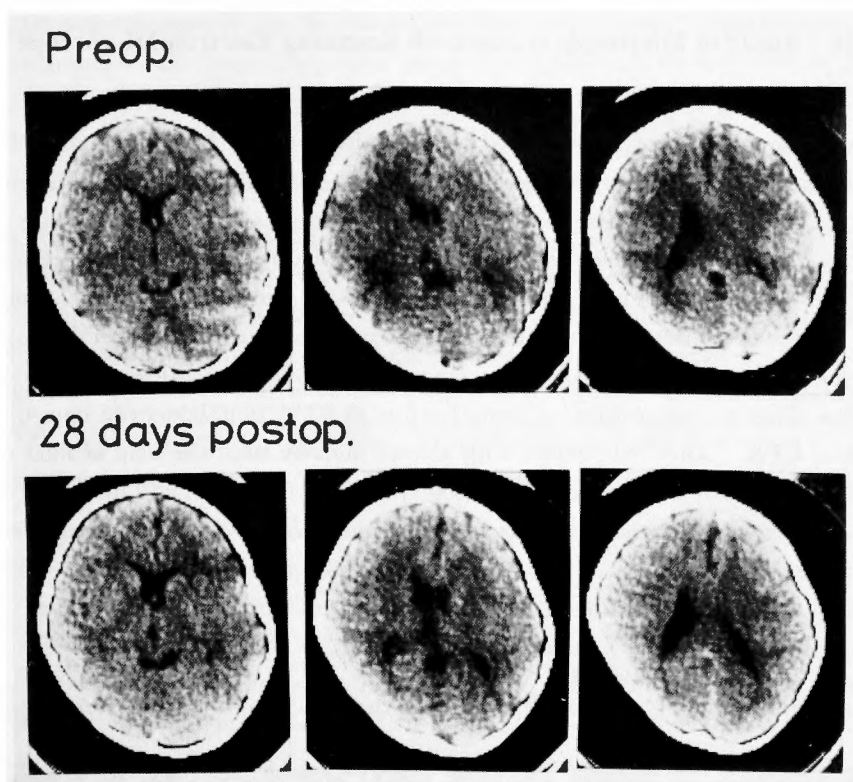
Preoperative and postoperative CT scans of the brain of a 7-year-old girl with tetralogy of Fallot. She had total correction combined with closure of a Waterstone shunt and pulmonary valve replacement. Cardiopulmonary bypass with a membrane oxygenator lasted 189 minutes. There was no filter in the arterial line. No postoperative changes were noted.
